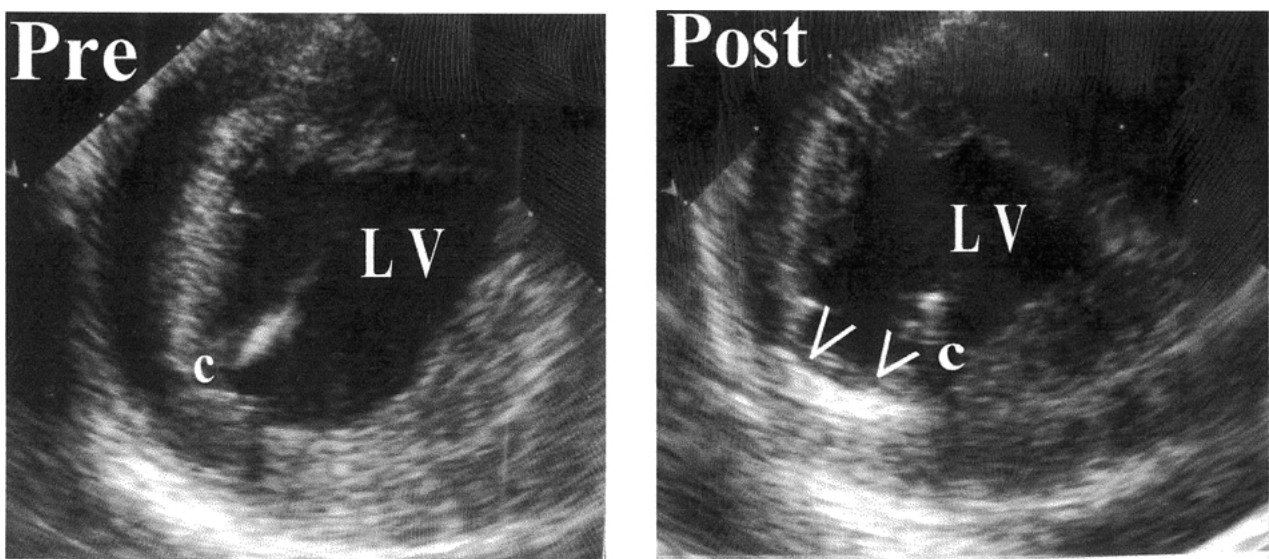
Intracardiac echocardiographic images of the LV showing needle application and ablation. The left panel shows the catheter (c) positioned prior to ablation. In the right panel, the catheter has been withdrawn slightly after lesion deployment. The lesion (arrowheads) is marked by tissue swelling and increased echo density.
